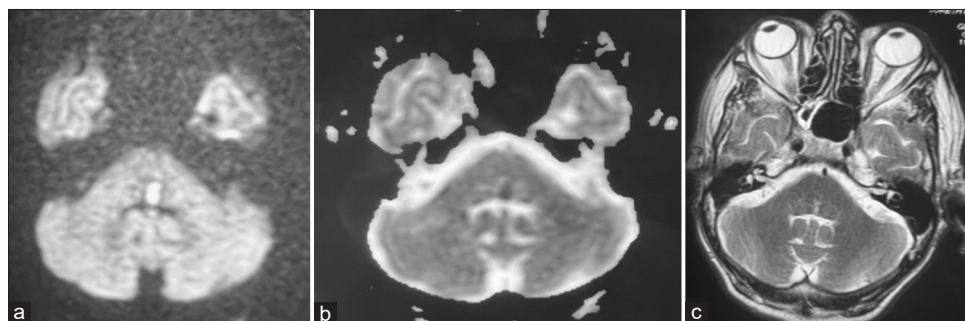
(a) MRI brain axial diffusion-weighted image showing hyperintensity (diffusion restriction) in left lower paramedian pontine tegmentum suggestive of acute infarct; (b) MRI brain axial apparent diffusion coefficient image showing corresponding hypointensity in left lower paramedian pontine tegmentum; and (c) MRI brain axial T2 weighted image showing corresponding hyperintensity
